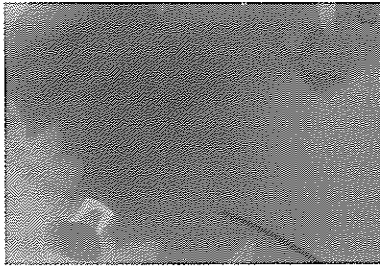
Radiograph after periapical surgery. The through-and-through osseous defect was created.
